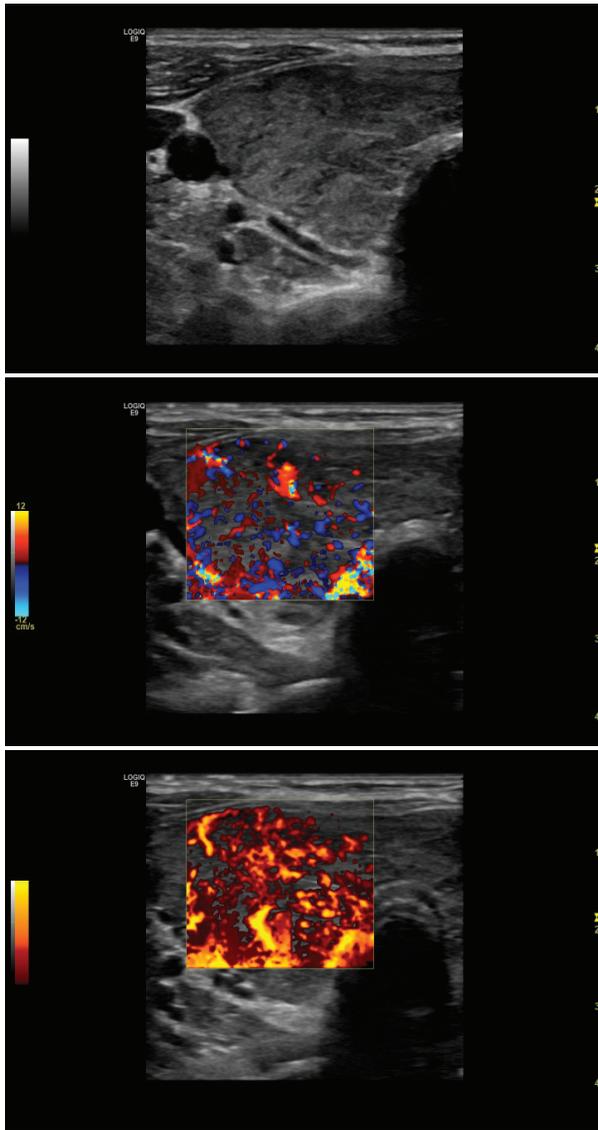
sonography of the thyroid gland in Graves disease: It is enlarged (goiter [p.d. > 18ml in women and > 25ml in men], here diffuse goiter, i.e. without knots), hypoechoic (i.e. it has the same echogenicity as the neighboring neck muscles) and the pathognomonic hypervascularization can be seen in color duplex and in power mode ("vascular inferno").
